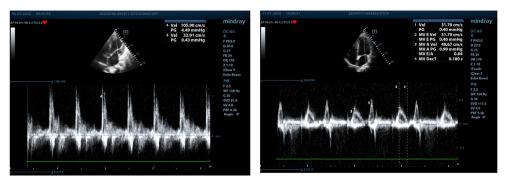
a.9. Evaluation of the diastolic function in presented case at first echocardiographyc evaluation (left: type 3 dyastolic dysfunction pattern, E/A= 3.19) and after 6 months (right: type 1 dyastolic dysfunction pattern, E/A= 0.64) (PW Doppler, 4-chambers view)
